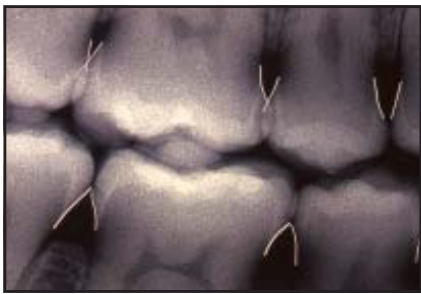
(top left) Radiographically, proximal contours of teeth are slightly concave or flat from the CEJ to the proximal contact.
